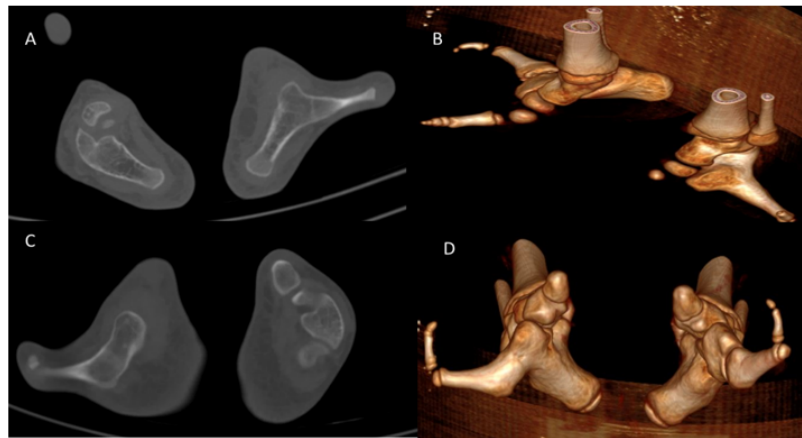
CT images in bone window (A, C) and in 3D reconstruction (B, D), showing ectrodactyly of both feet.
